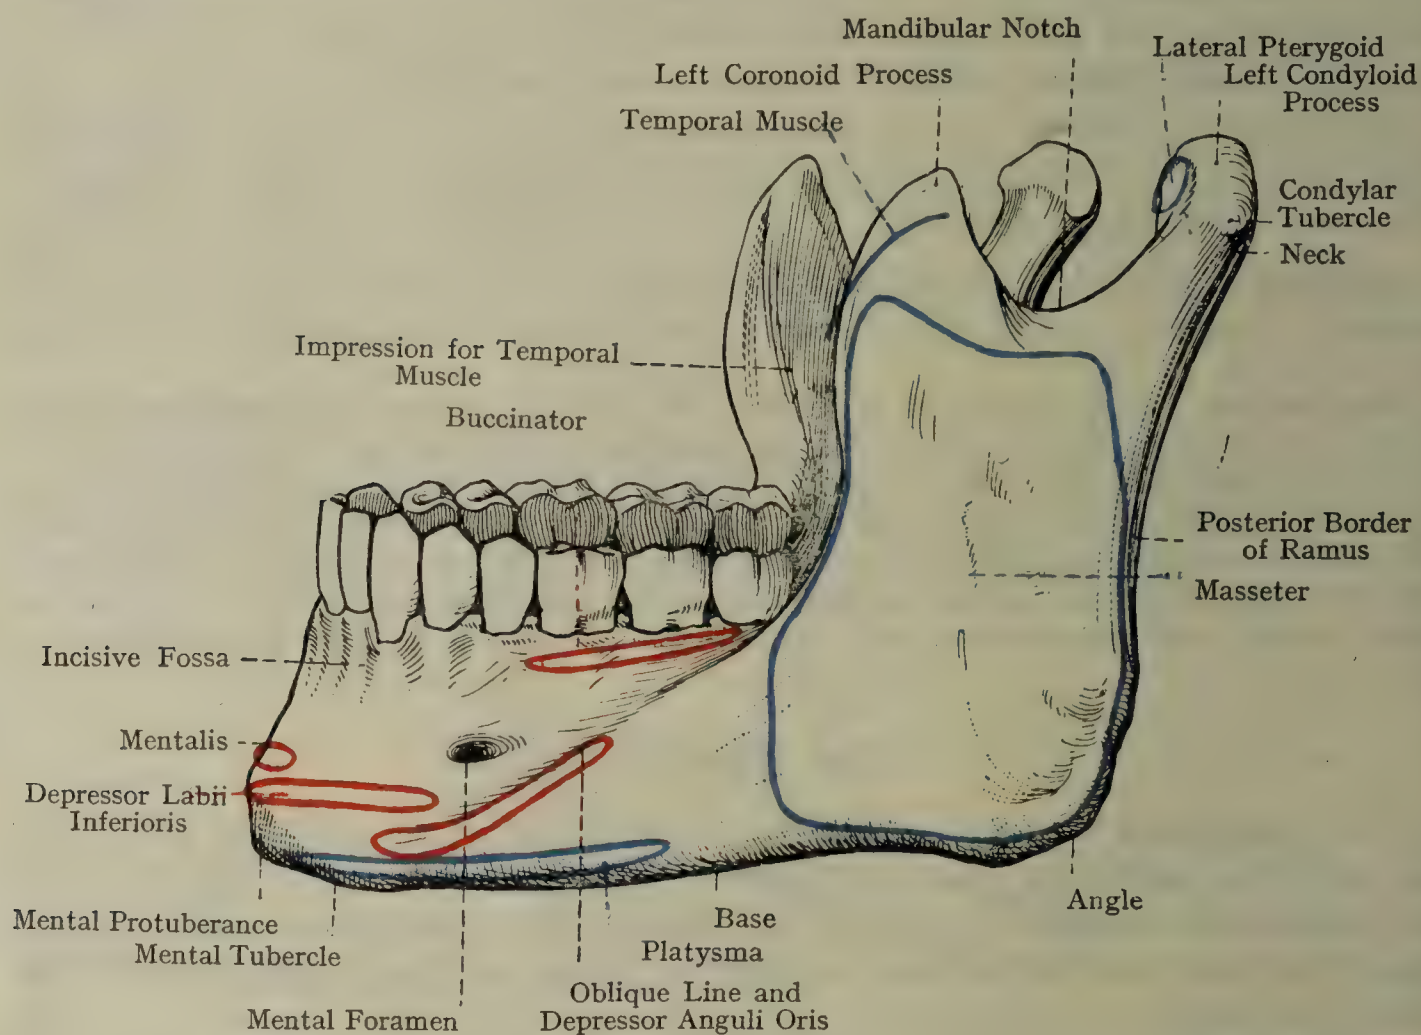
THE LEFT HALF OF THE MANDIBLE (LATERAL ASPECT).
